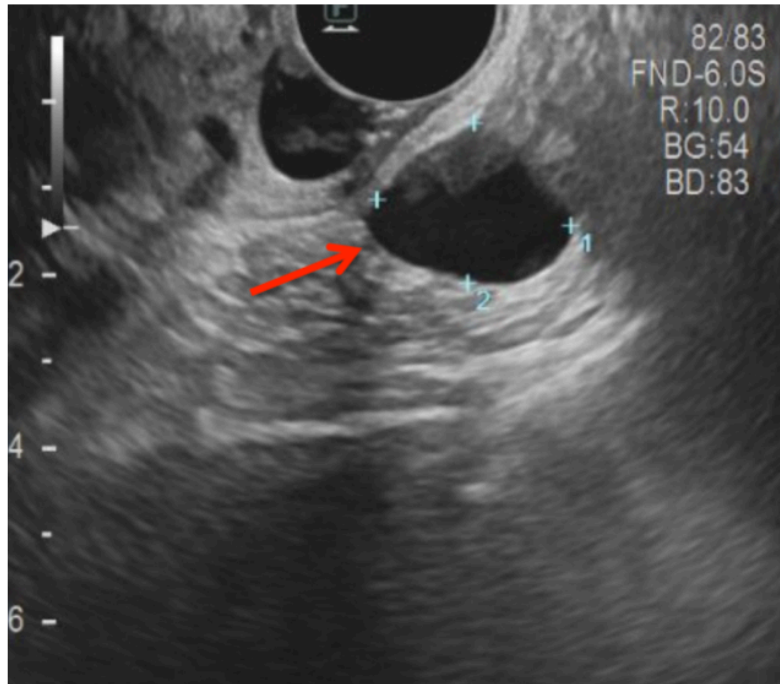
Endovaginal ultrasound showed a simple cyst (red arrow) measuring $2.2 \times 1.8 \times 2.5$ cm was identified in the cul-de-sac region.
